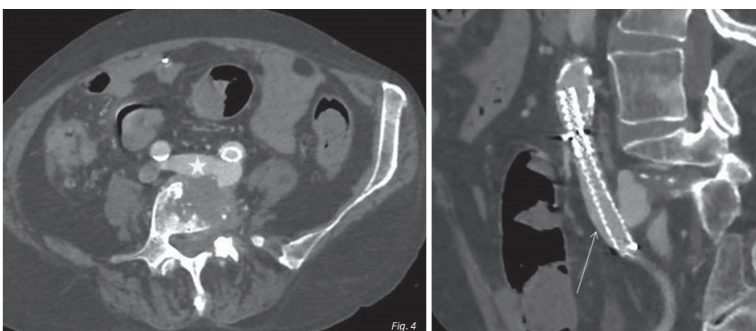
Post-surgical, axial (left) and sagittal (right) CT, arterial phase, after repair at L4-L5 level. There is absence of venous congestion (asterisk) after stenting of the left common iliac artery (arrow).
